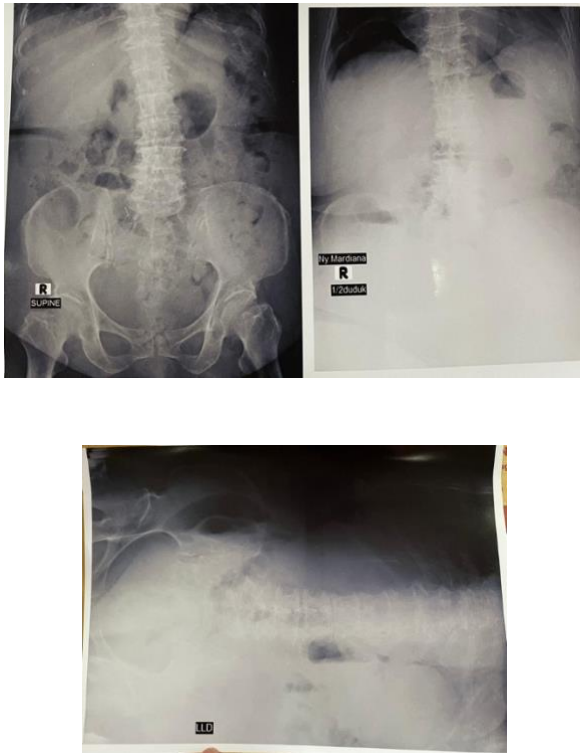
Abdominal x-ray showed pneumoperitoneum.
